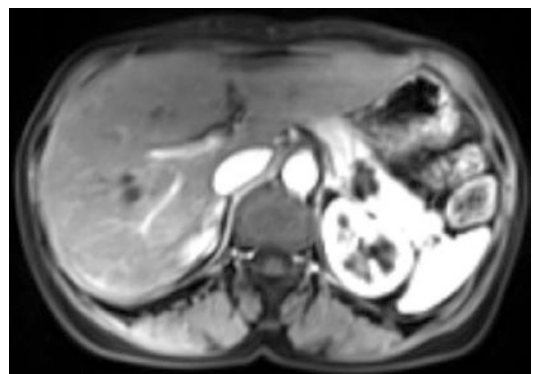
MRI image showed a cystic mass in the distal pancreatic lesions
